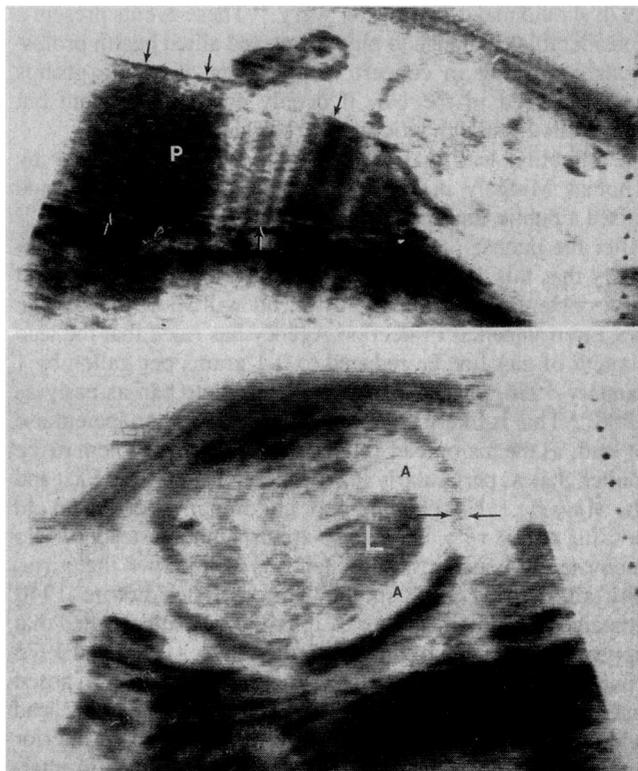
Top, A longitudinal ultrasound scan shows pronounced placental (P) thickening (8 cm) and polyhydramnios. The margins of the placenta are indicated by arrows. Bottom, A transverse scan of the fetal abdomen shows moderate ascites (A). The liver (L) and bowel are outlined by fluid. The thickened abdominal wall is indicated by arrows.
